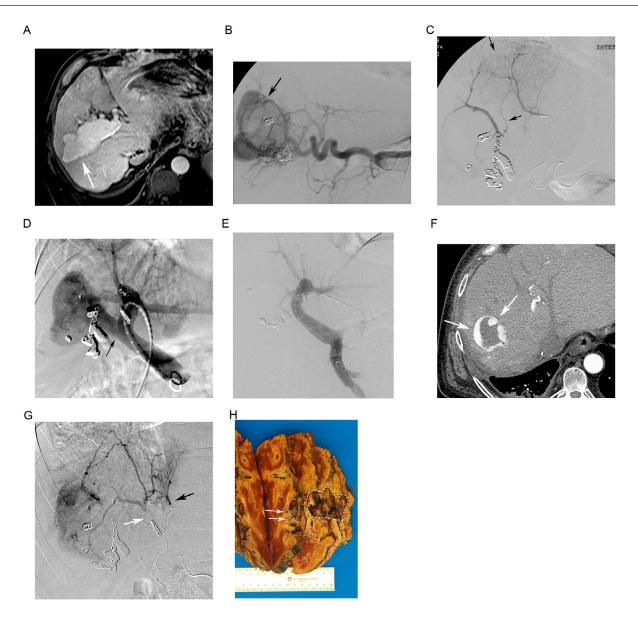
Images of a 65-year-old man status post-OLT 16 years prior with abdominal pain. (A) Axial contrast-enhanced MR image demonstrates arterial-phase enhancement of the right portal vein with an associated 6.4 x 5.8 cm PVA (arrow). (B) Celiac angiography following coil embolization of multiple subsegmental RHA contributors shows persistent perfusion of the PVA (arrow) via additional branches of the RHA. (C) On angiography 1 month later, collateral reconstitution (arrows) of RHA branches have developed from the LHA. (D) Portal venography 4 months after initial angiography opacifies the right PVA with origin (arrow) measuring 2.2 cm in diameter. (E) Following stent-graft placement portal venography confirms exclusion of the PVA with preserved flow within the superior mesenteric vein and left portal vein. (F) Axial contrast-enhanced CT image 6 months after stent-graft exclusion demonstrates arterial-phase peripheral enhancement of the PVA (arrows). (G) Subsequent angiography confirmed a type 2 endoleak supplied by branches of the segment 4 hepatic artery (black arrow) reconstituting branches of the RHA distal to coils (white arrow). (H) Representative gross pathologic section of the PVA (dashed outline) with multiple adjacent embolized feeding vessels (arrows) containing coils.
